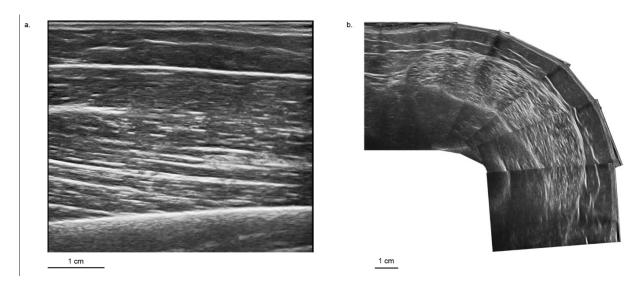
Ultrasound images of the upper arm and the thigh. a. Ultrasound image of the upper arm (Sagittal); b. Ultrasound image of the thigh (cross-sectional).
